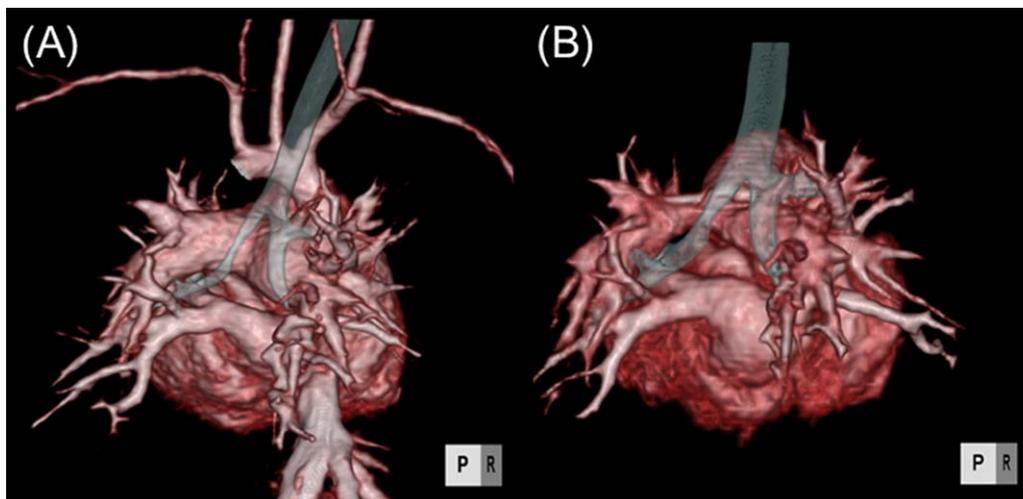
Representative three-dimensional computed tomography images. Before (A) and one month after the total correction (B) images of the same patient who underwent the operation at the neonatal period
